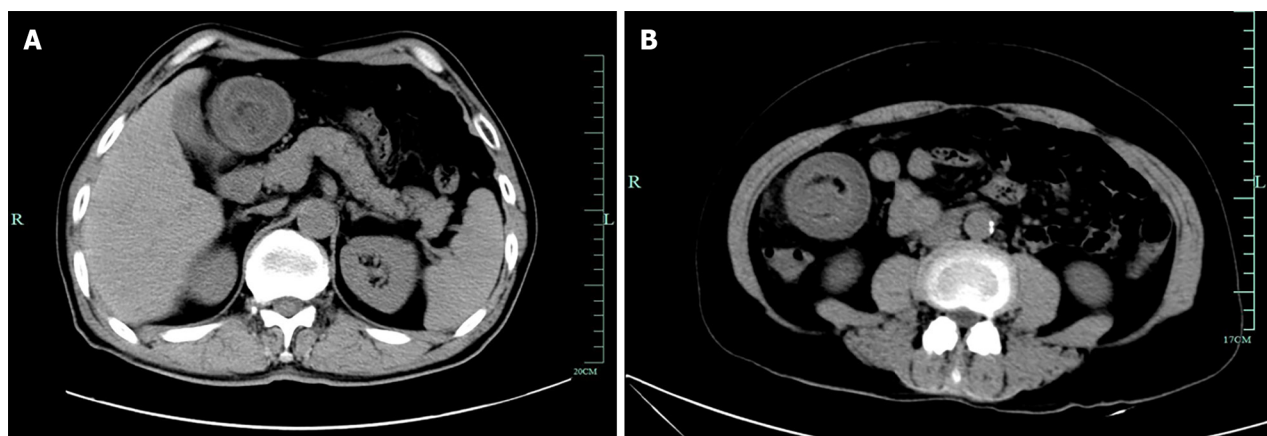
Urgent abdominal computed tomography. A: Urgent abdominal computed tomography (CT) revealing a colo-colonic intussusception near the hepatic flexure; B: Emergency abdominal CT revealing a target-like lesion with thickened intestinal walls.
